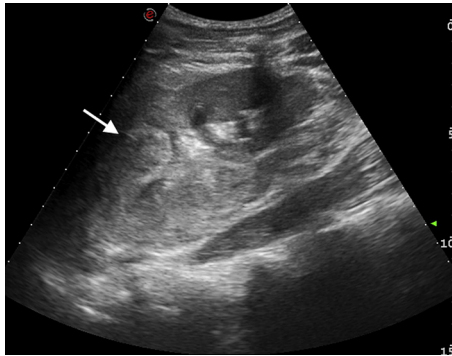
Abdomen ultrasonography was not able to identify a normal structure of the upper pole of the left kidney, which appeared to be replaced by a large hematoma (arrow).
